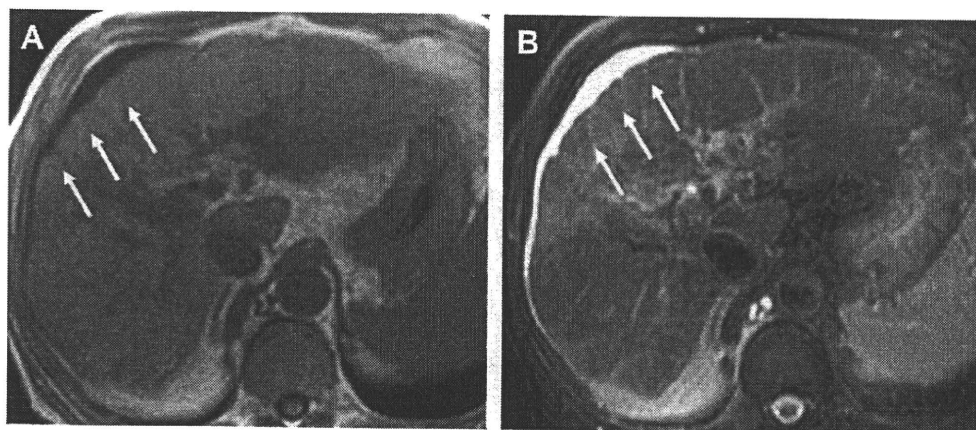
T1-weighted GRE in-phase (TE, 4.7 ms) image and T2-weighted fat-saturated TSE image shows fibrotic septa and bridges as reticulations. The reticulations (arrows) are observed as hypointense on T1-weighted images (A) and as hyperintense on T2-weighted images (B).
